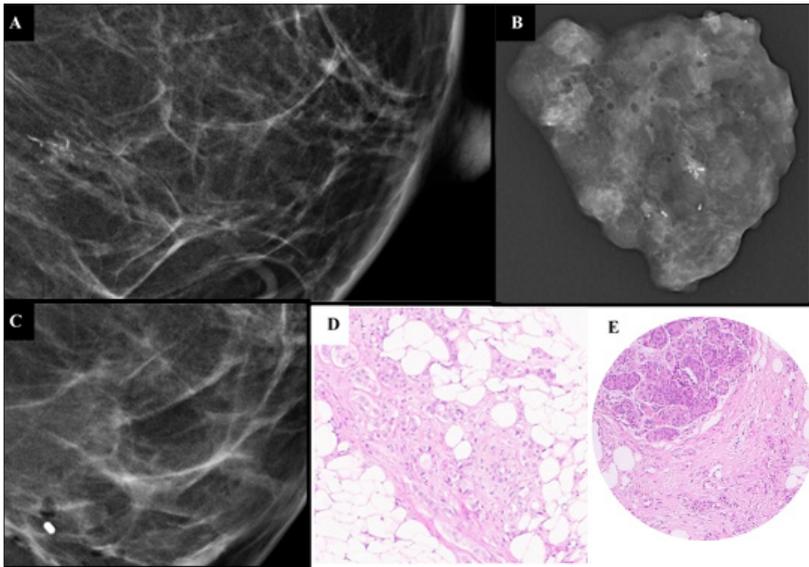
(A-E) - Mammography (A – cranio-caudal view) shows a cluster of microcalcifications, some with a fine linear morphology, located at the union of the internal quadrants of the left breast, measuring 16 mm (longest axis). Stereotactic-guidance vacuum-assisted biopsy was performed, with radiography of the fragments (B) and placement of a clip (C). The anatomopathological diagnosis (D, E) showed invasive carcinoma of no special type associated with an extensive component of high-grade ductal carcinoma in situ with necrosis and microcalcifications (photo E showing the two components – in situ and invasive).
